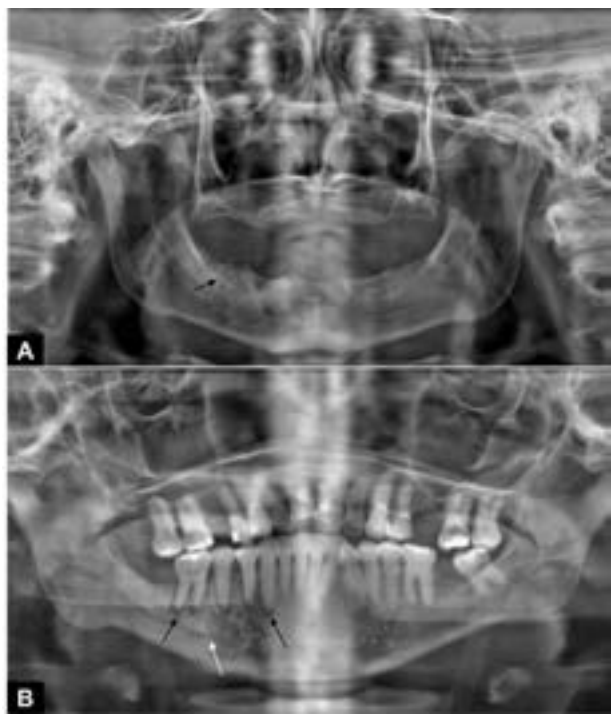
Panoramic radiograph of two patients with clinical and radiographic diagnosis of MRONJ; A- Change in the trabeculae, with increased medullary spaces in the posterior region of the right jaw (black arrow); B- Increase of space corresponding to the periodontal ligament of teeth 43 to 46 (white arrows), associated to the integrity of the bone crest of these elements and absence of probable odontogenic cause. There is also a change in the bone trabeculae, with an increase in the number of bone trabeculae, in the posterior region of the jaw on the right side, extending from the mesial of tooth 45 to the mesial root of tooth 46.
